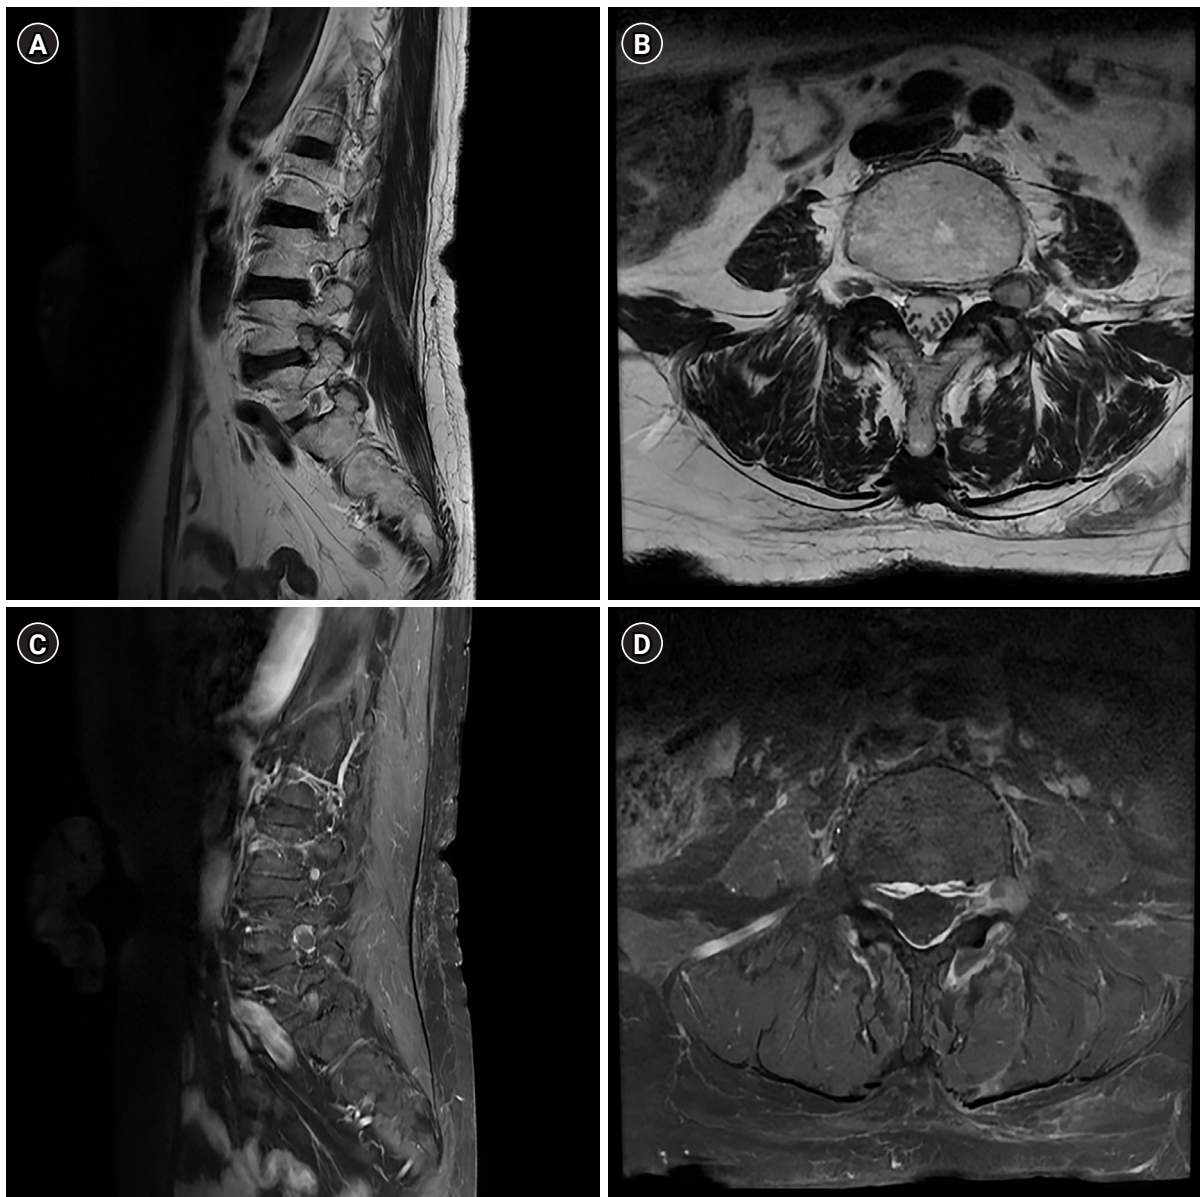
Magnetic resonance finding of the tumor. (A) The tumor-like lesion demonstrated high signal intensity on T2-weighted imaging. (B) Low signal intensity on T1-weighted imaging. (C, D) Peripheral enhancement on T1-enhancement imaging.
